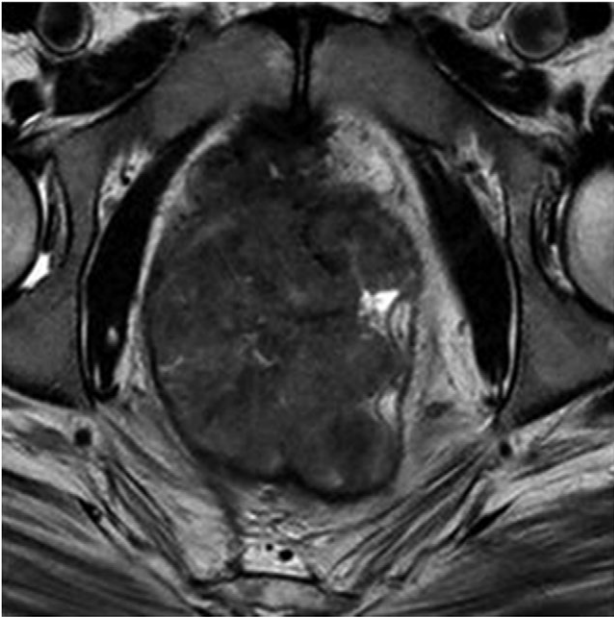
MRI pelvis. T2 waited axial image through lower pelvis through the large polypoid rectal tumour with T3 extension involving the CRM.
